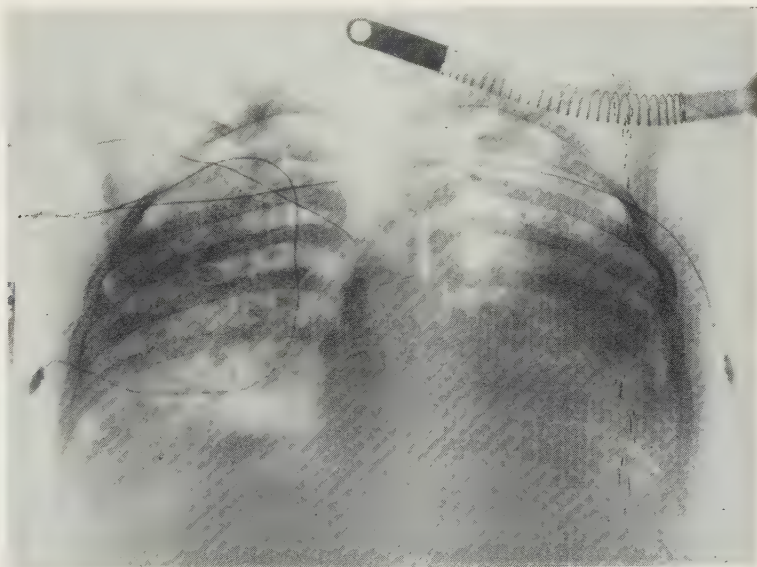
Case 4. Effect of positive end-expiratory pressure on chest X-ray picture.
